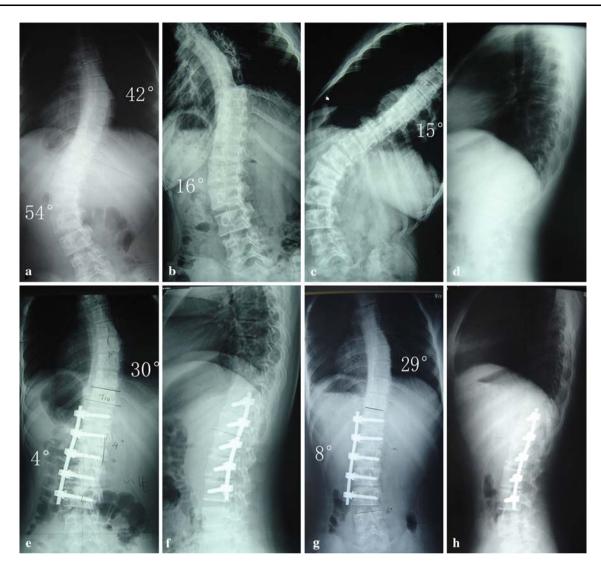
A 14-year-old female patient with AIS Lenke type 5 curve (patient no. 20). a Preoperative Cobb angle of lumbar curve was 54°, thoracic curve 42°. Ration of L:T was 1.29. b Bending film of the lumbar curve was 16° with correction rate of 70.4%. c Bending film of the thoracic curve was 15° with a correction rate of 64.3%. d Lateral radiograph. e Anterior correction with single rod was
